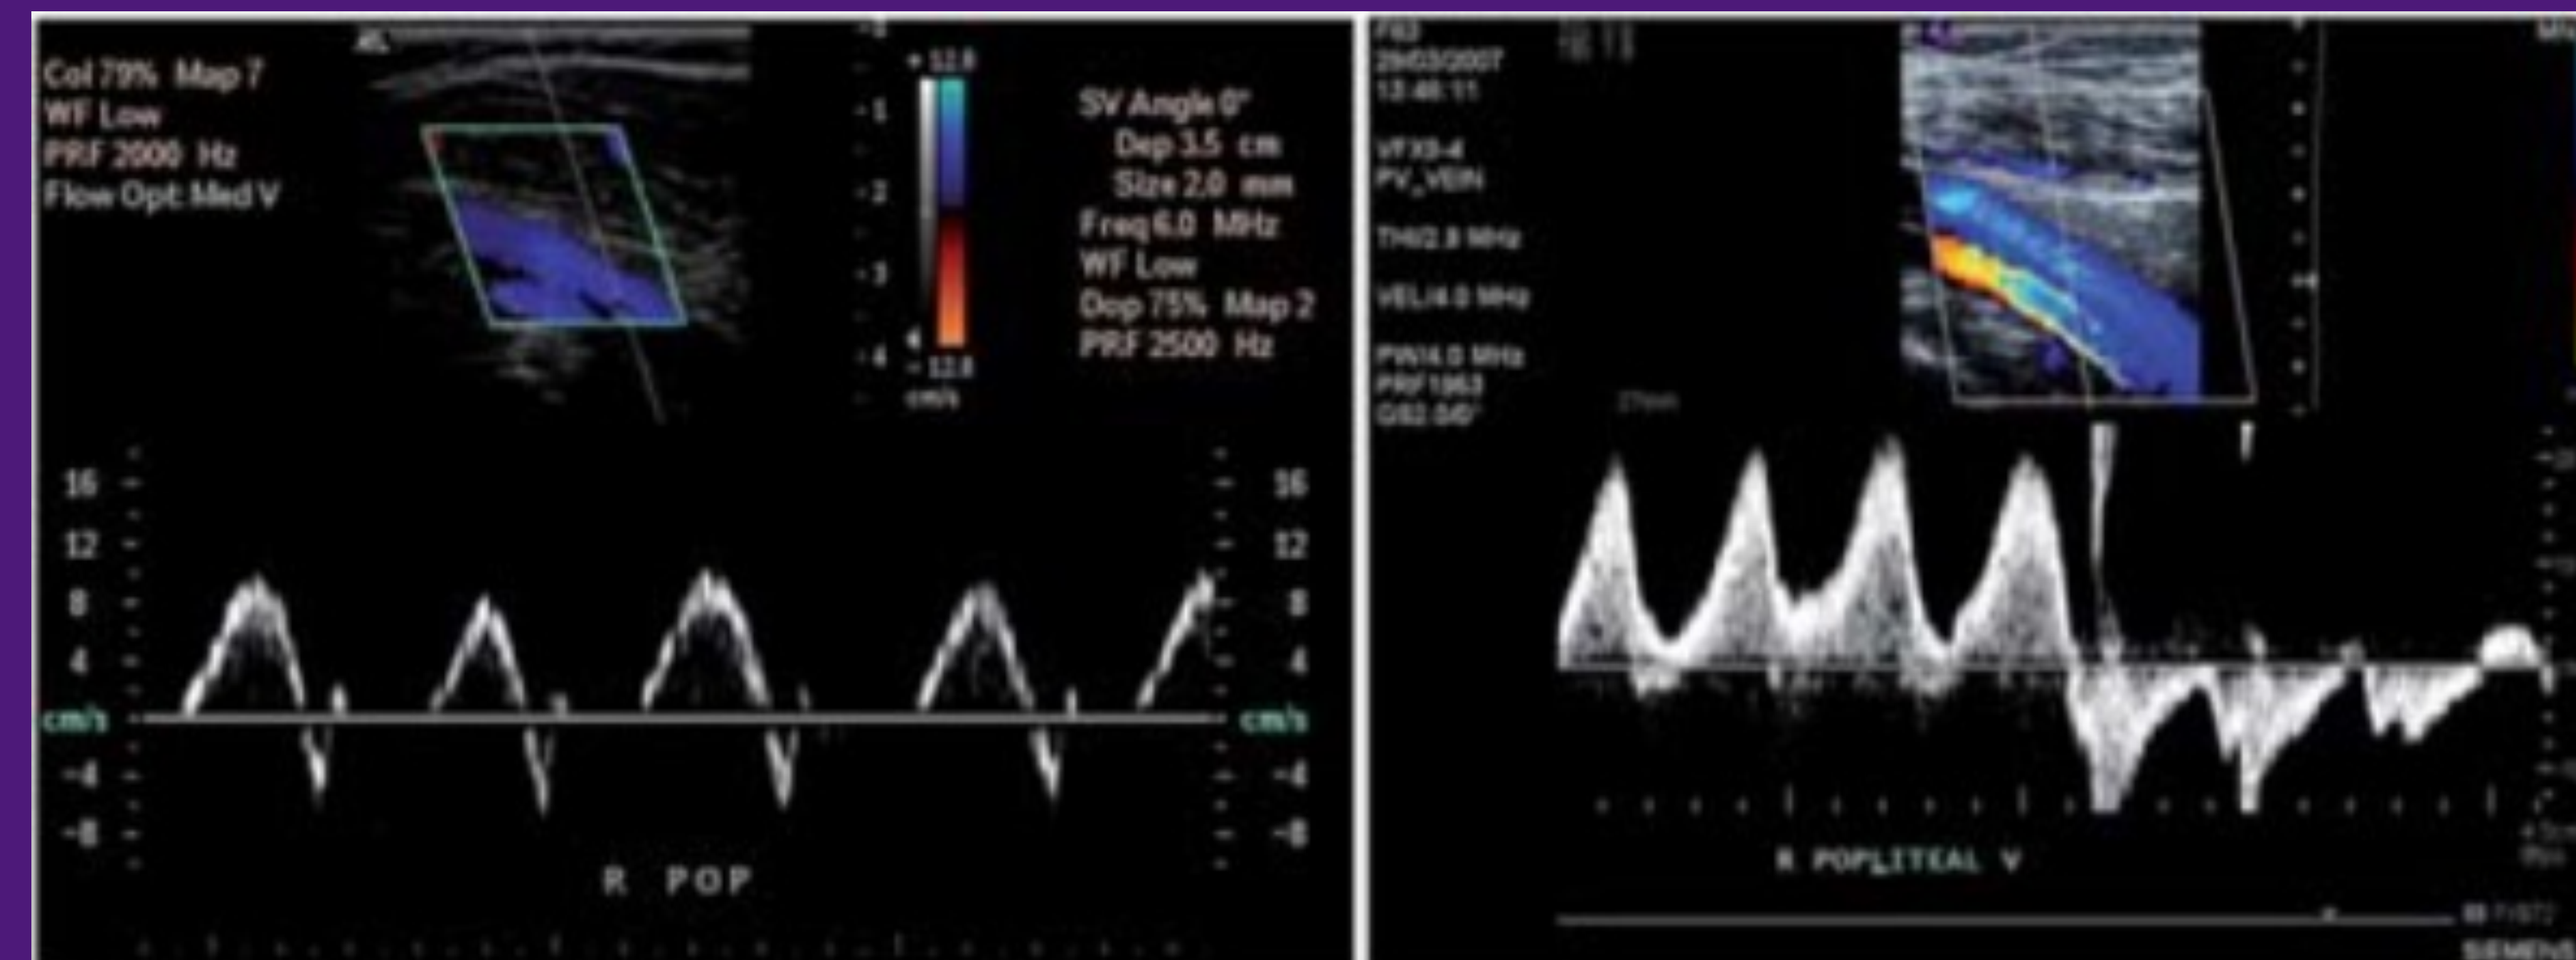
Duplex Ultrasound of the popliteal vein. Left: Normal popliteal vein. Right: Incompetent popliteal vein
